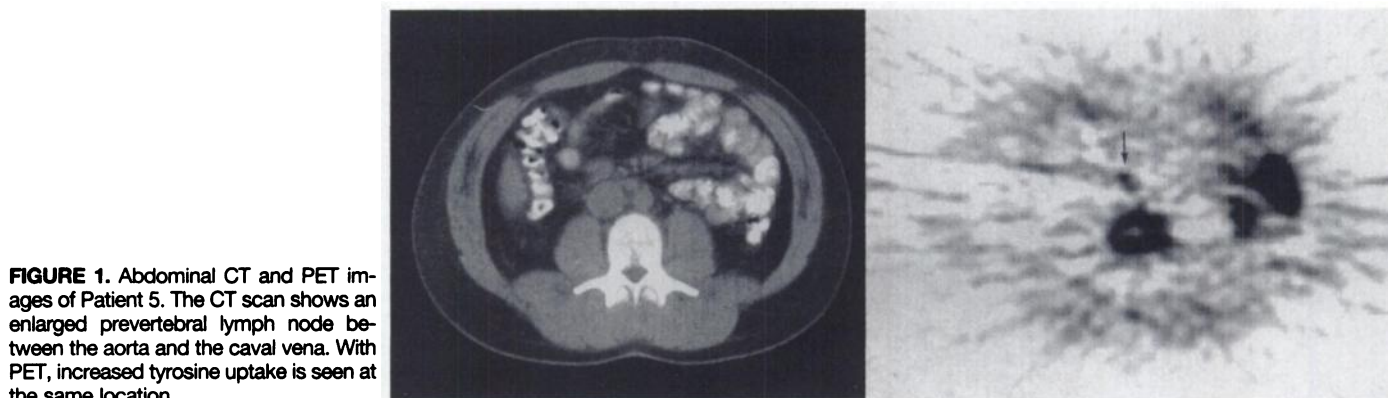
Abdominal CT and PET images of Patient 5. The CT scan shows an enlarged prevertebral lymph node between the aorta and the caval vein. With PET, increased tyrosine uptake is seen at the same location.
